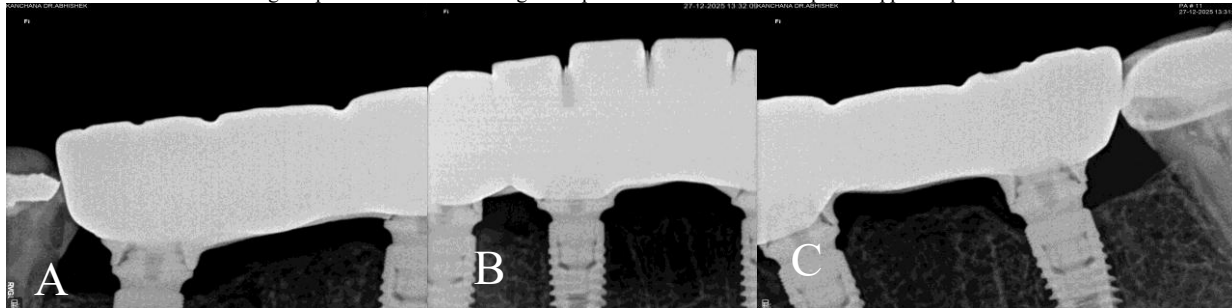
Case 1 Radiographic evaluation of the seating of the prosthesis.
